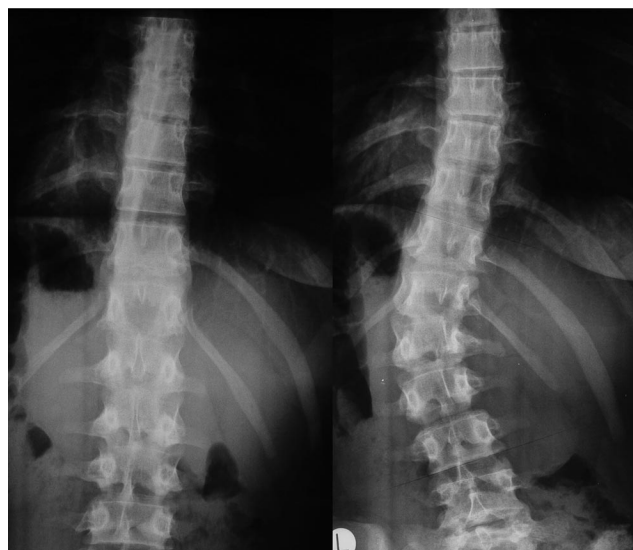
The standard posteroanterior radiographs of the spines of the twins revealed the existence of a left lateral convex thoracolumbar curve of 32° in only one of them.
